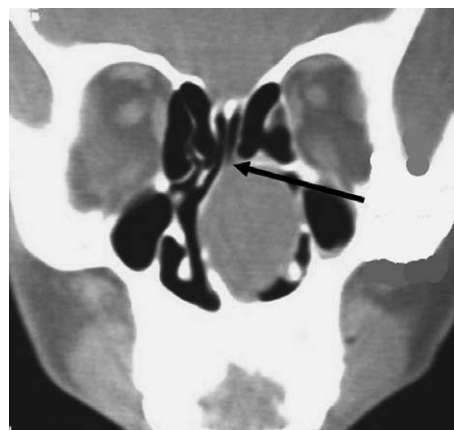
Coronal CT scan of the paranasal sinuses showing a polypoid mass arising from the roof of the nose (arrow), with clear paranasal sinuses.
